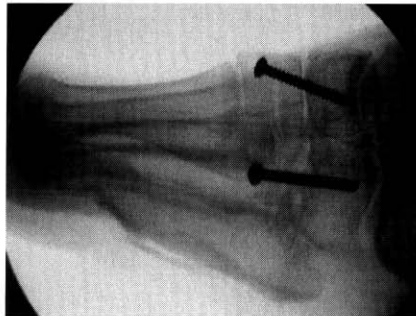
Cole midfoot osteotomy lateral radiographic view after screw fixation.
